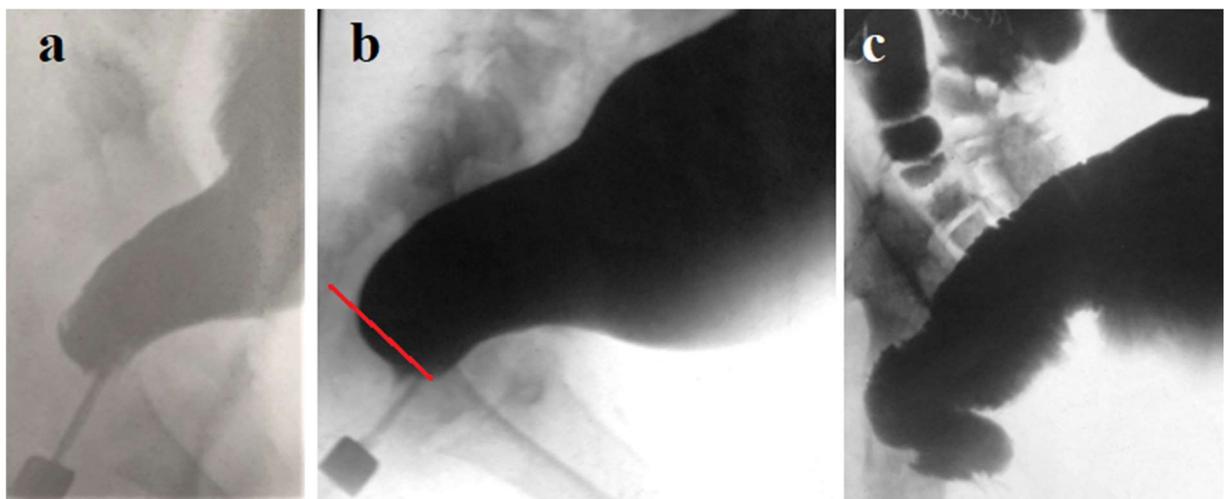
Radiographs of anorectum in patients with HD without segmental contractions. In each case, the rectosigmoid ratio is <1 . On radiographs (a, b) in children over 5 years of age, the width of the rectum (a) is 2 cm, (b) - 3 cm, with a minimum age width of 3 cm. The length of the anal canal is within the age norm, and the axis of the anal canal coincides with the rectal axis. (c) The contours of the rectum are finely toothed, indicating an inflammatory process.
